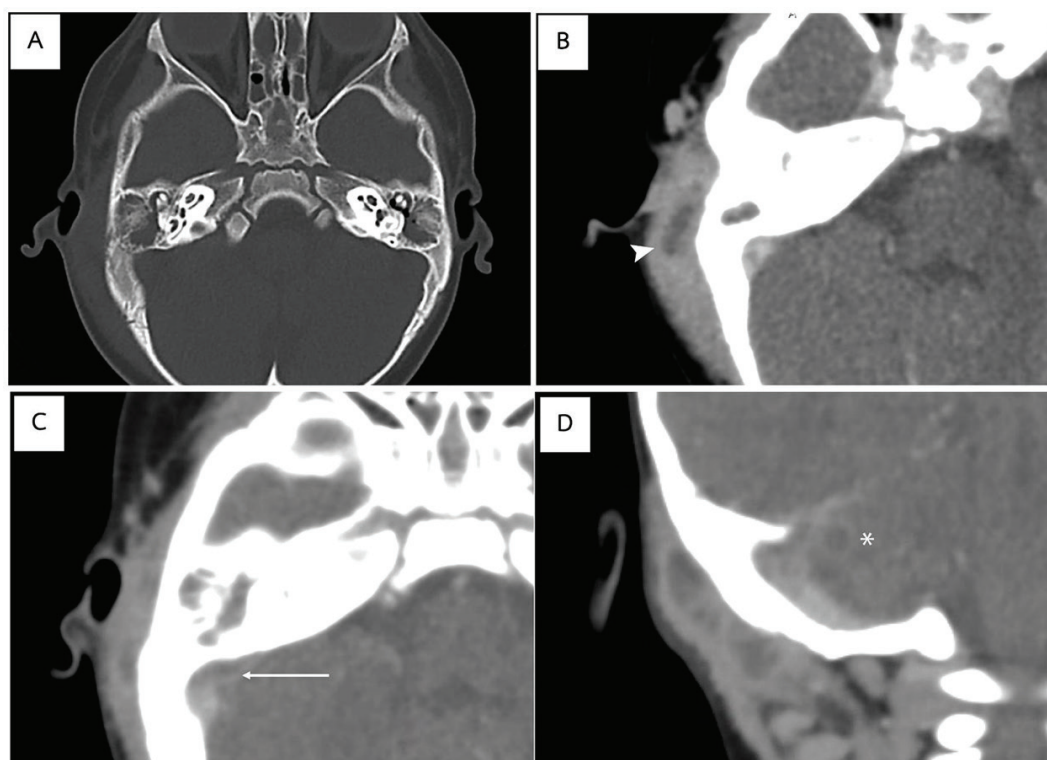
(A) Bone window temporal bone CT showing fluid density in both middle ears and mastoids, with greater severity on the right side (B) Contrast-enhanced brain CT demonstrating a right subperiosteal abscess (arrowhead) (C) Right lateral sinus thrombosis showing the characteristic empty delta sign (arrow) (D) Small right cerebellar abscess (asterisk)
